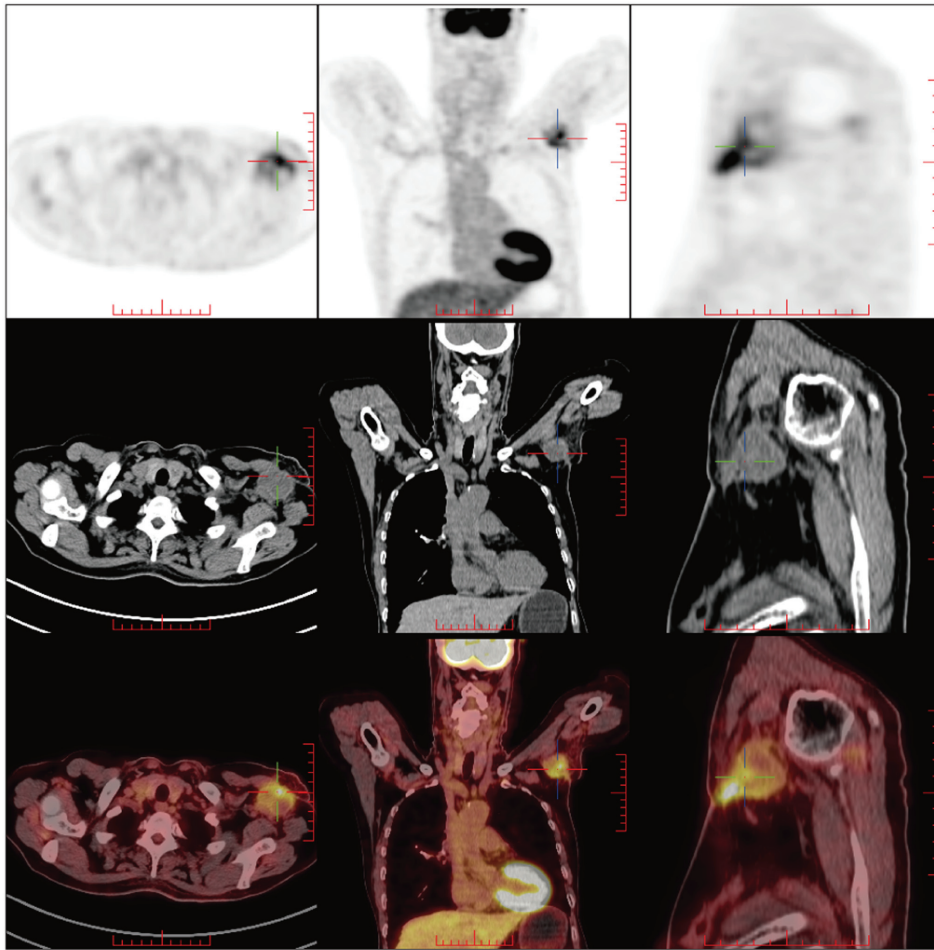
¹⁸F-FDG-positron emission/computed tomography demonstrated an FDG-avid lesion that measured 3.6x3.4x3.4 cm. ¹⁸F-FDG, ¹⁸F-fluorodeoxyglucose.
